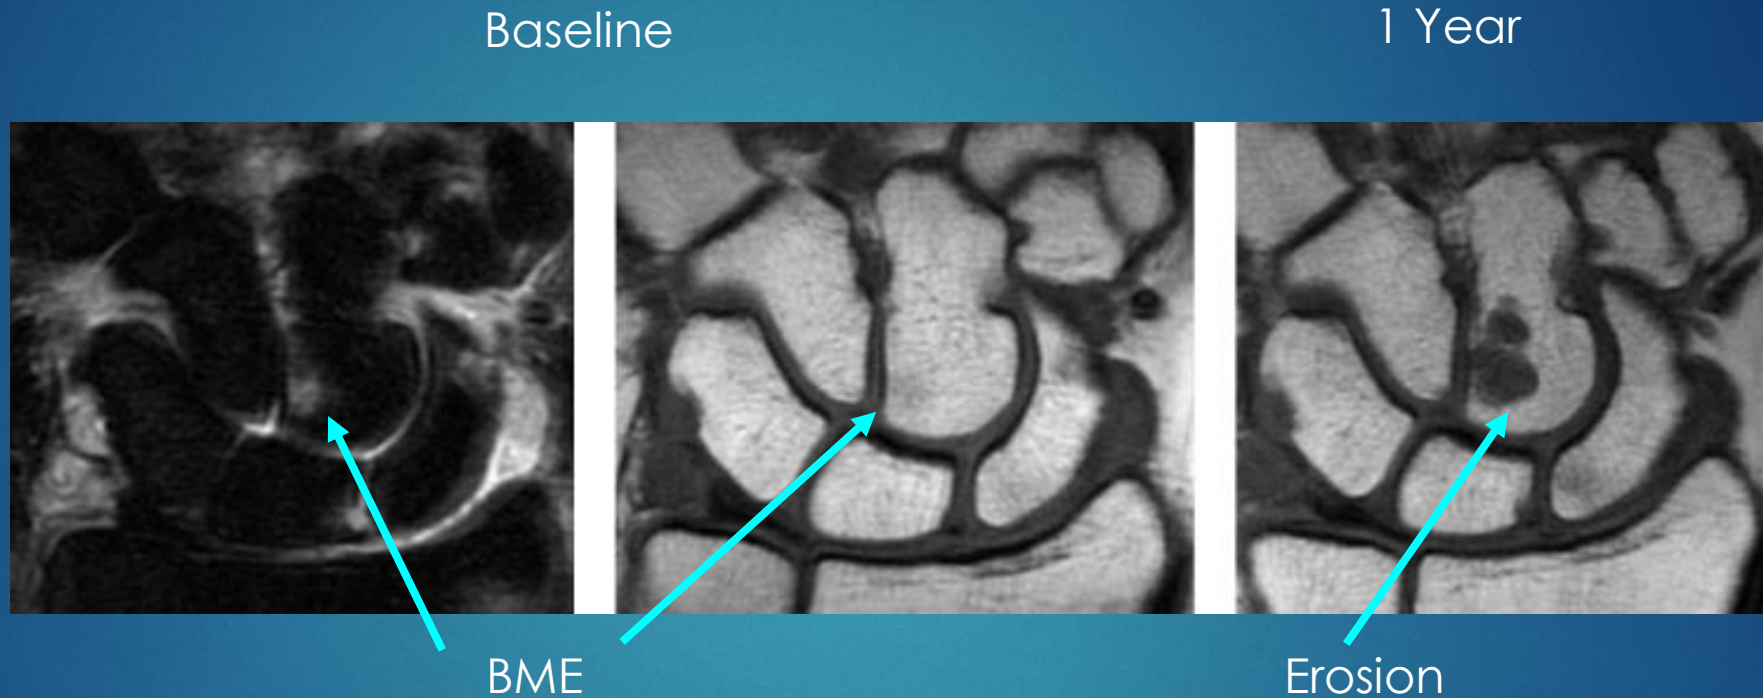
Magnetic resonance imaging (MRI) of the wrist, at baseline (A, B) and 1-year follow-up (C). (A) Baseline coronal STIR image showing bone marrow in the capitate (thick arrow) and the lunate and trapezoid (thin arrows). (B) Baseline T1-weighted image without MRI erosion in the capitate (arrow). (C) T1-weighted image at 1-year follow-up, showing erosive progression in the capitate (arrow). Erosive progression was also seen in the trapezoid and the lunate, even though not optimally displayed in the presented slices.
